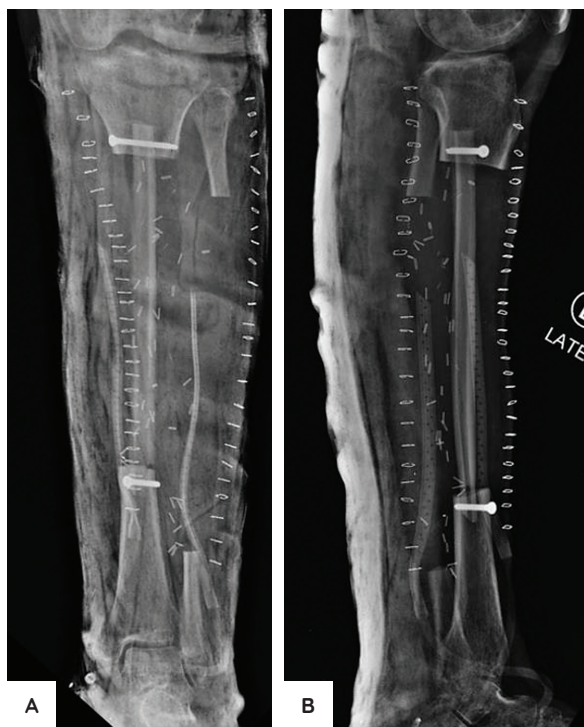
AP (A) and lateral (B) immediate postoperative radiographs showing the fibular strut graft fixated with two cortical screws.
